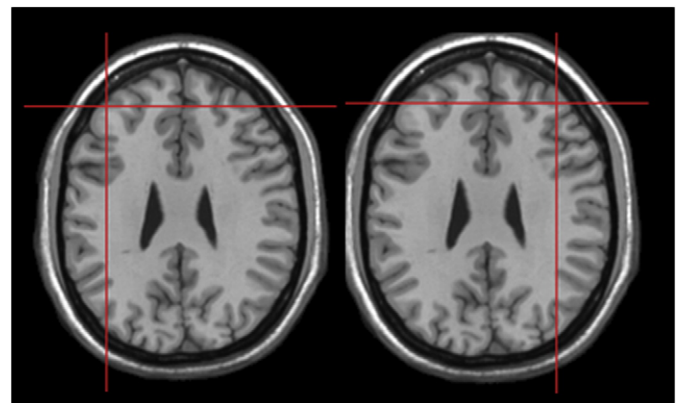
Axial MRI-constructed stereotaxic template of a representative subject indicating the left and right site of stimulation. Crosses indicate the position of the TMS coil at which rTMS was administered.
